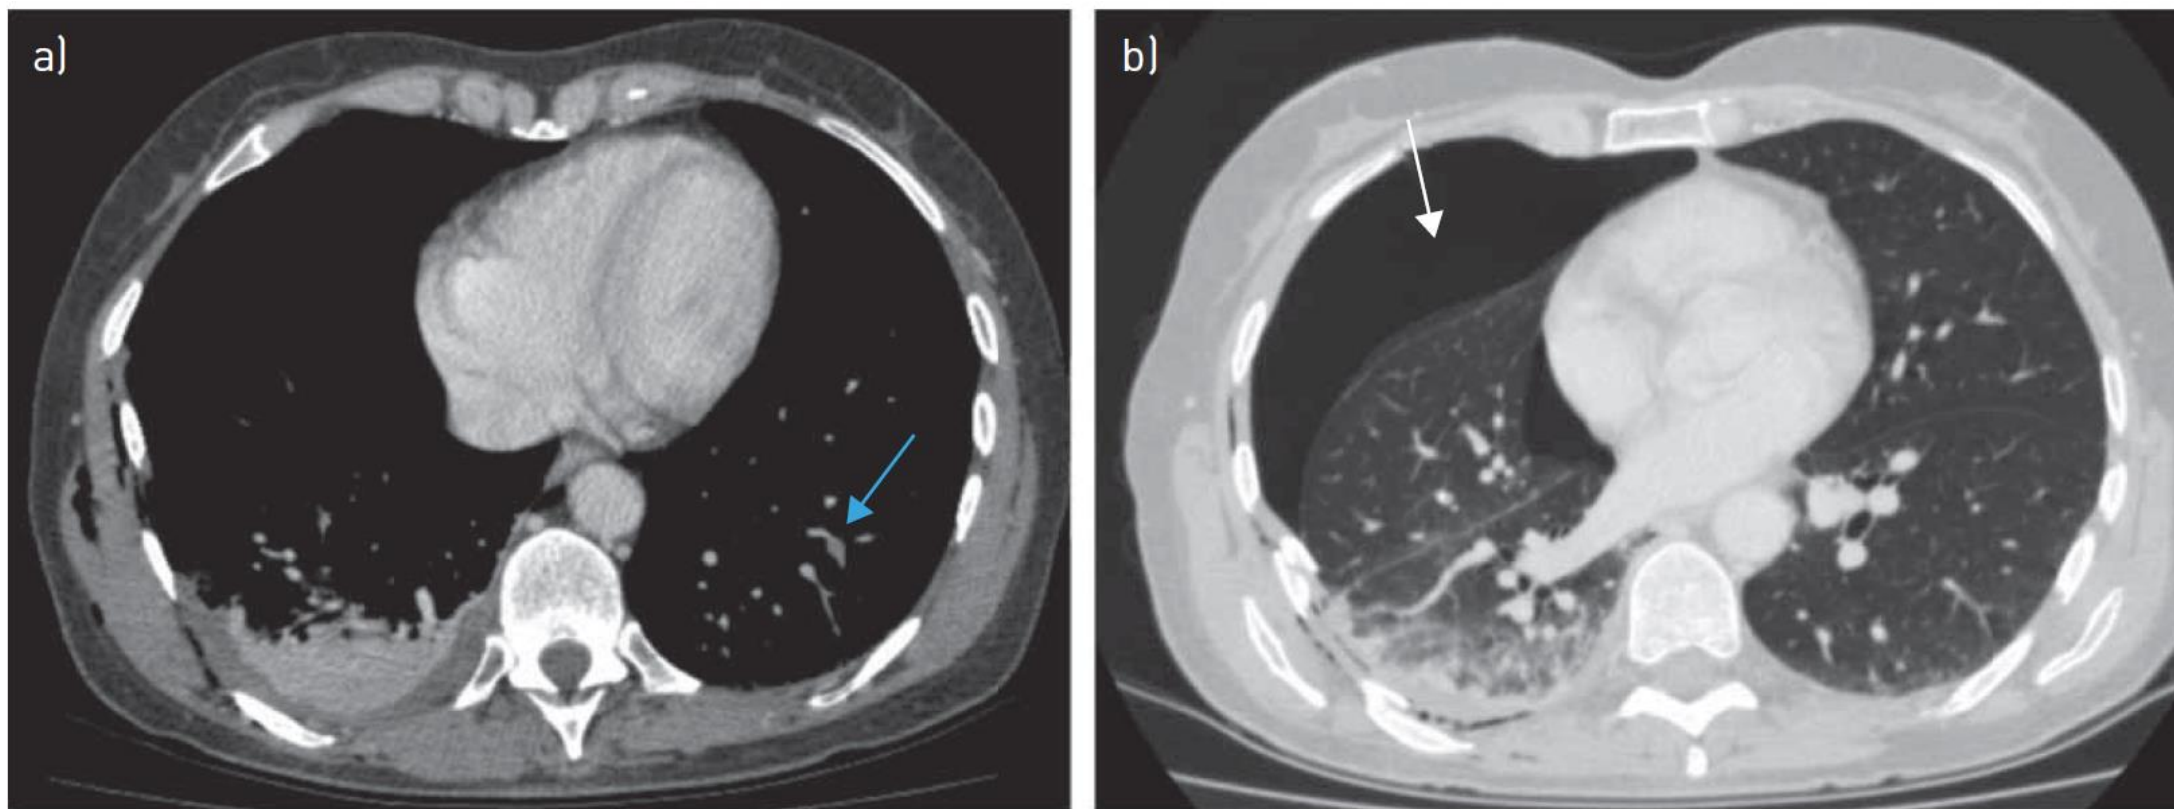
Chest computed tomography (CT) scan of patient from the clinical case. The blue arrow in panel (a) shows a filling defect in a left subsegmental pulmonary artery. Panel (b) demonstrates the pneumothorax (white arrow) and multiple costal fractures on the right side.
